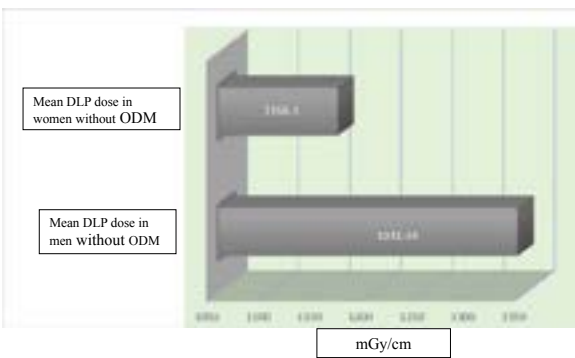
Comparison of the mean DLP values between men and women in the CT examination without and with the administration of a contrasting agent, without ODM
